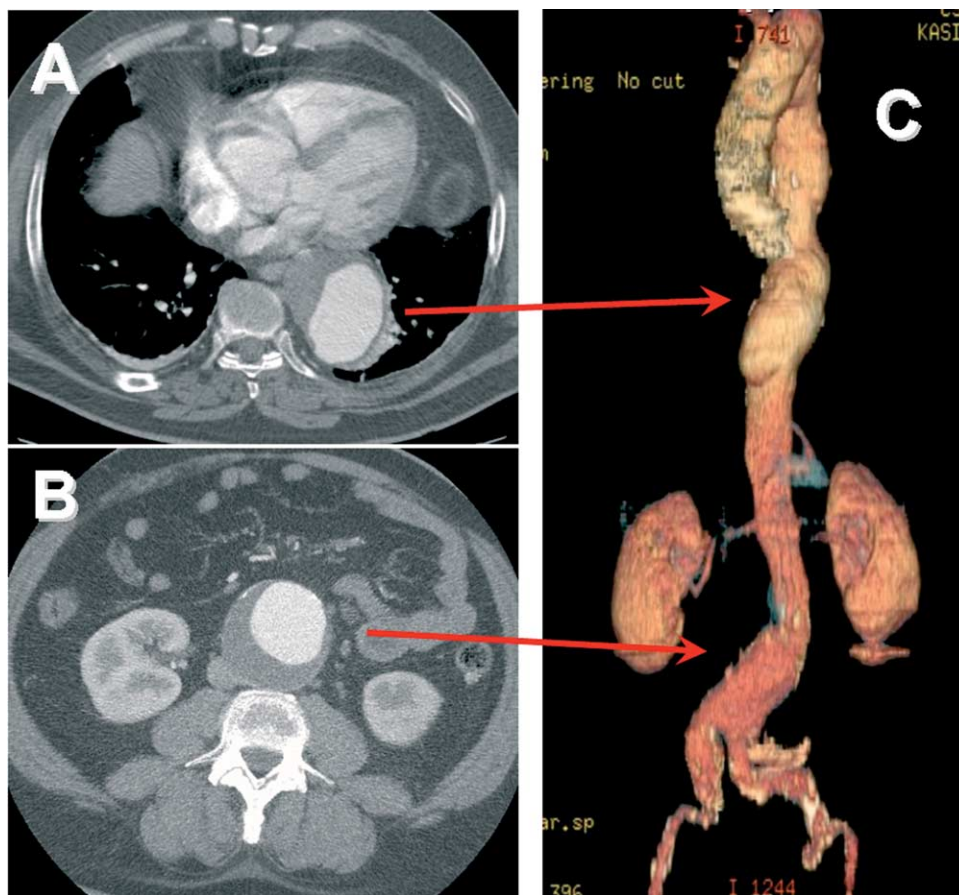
CT of patient with TAA (A) and AAA (B) with 3D angio-reconstruction (C).
